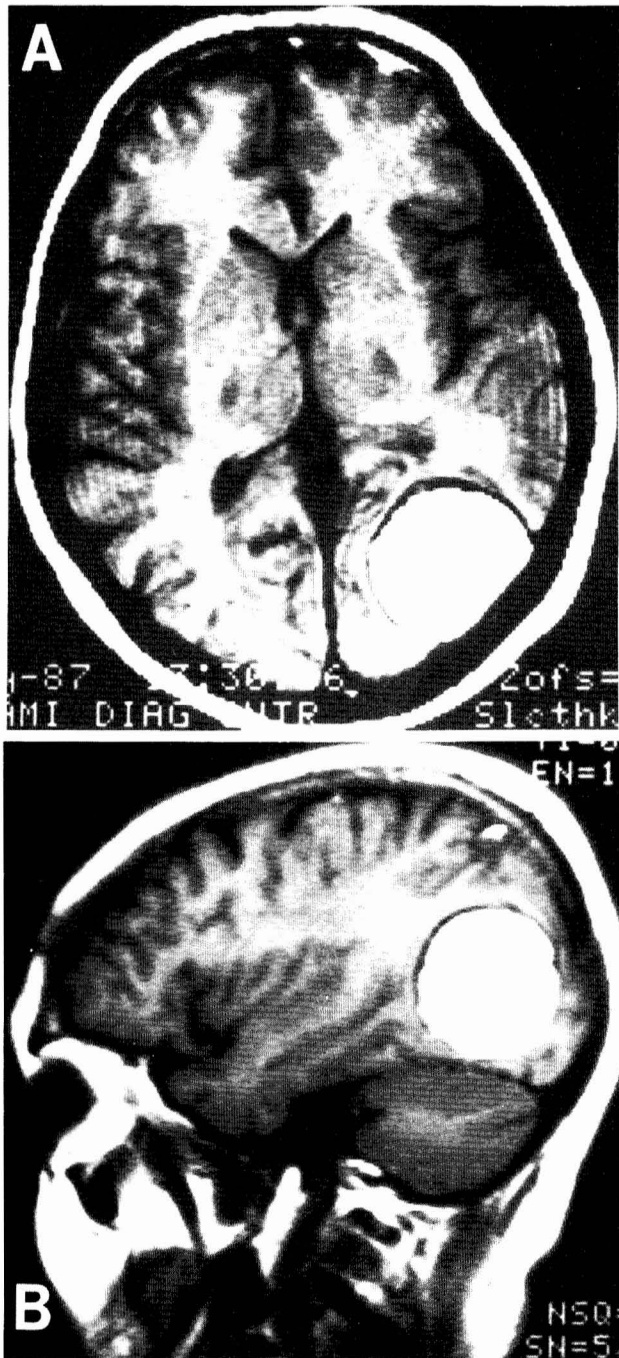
Case 2. Transverse (A) and sagittal (B) MRI scans (T1-weighted) demonstrating the uniform appearance of lipid density in the tumor. Note the clear distinction of the tumor from the surrounding brain.
